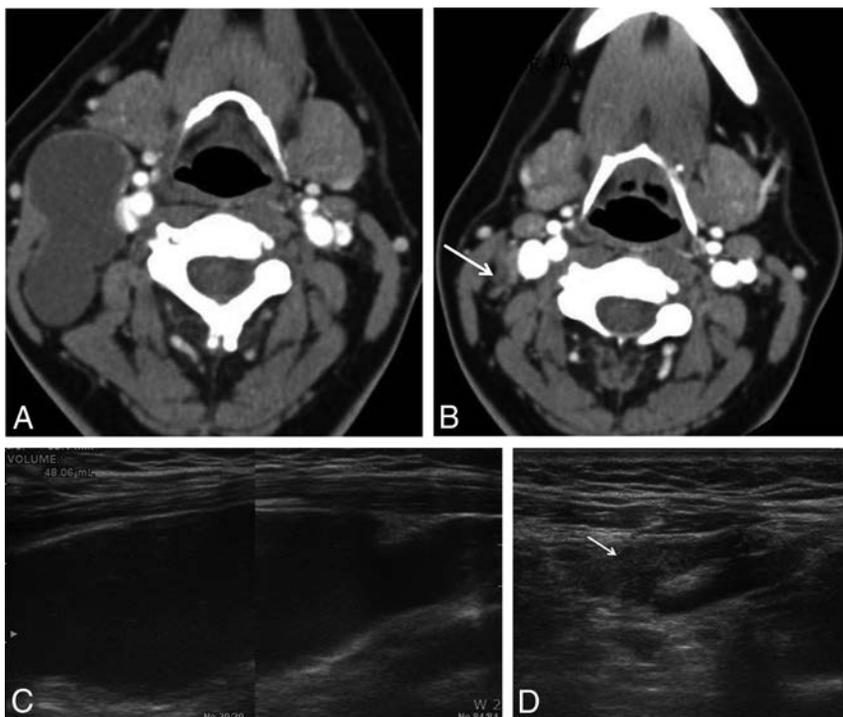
A 22-year-old woman with a right-neck mass. *A*, A CT scan reveals a 6.5-cm second branchial cleft cyst anteromedial to the sternocleidomastoid muscle and lateral to the carotid sheath. *B*, After 3 sessions of ethanol ablation, it is nearly obliterated on follow-up CT (*arrow*). *C* and *D*, Transverse sonogram also shows a large cystic mass in the right neck (volume, 48.1 mL) nearly disappeared after the treatment (*arrow*).
